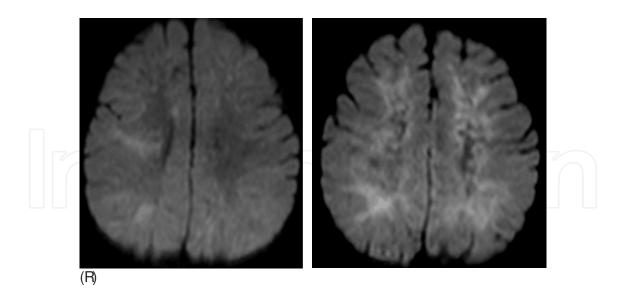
A 10-month-girl with HHV-6 encephalopathy; Lt, MRI DW on the 2nd day after onset showed high intensities at the right parietal and occipital lobes; Rt, 10 days later, the high intensities extended bilaterally into diffuse white matter.
